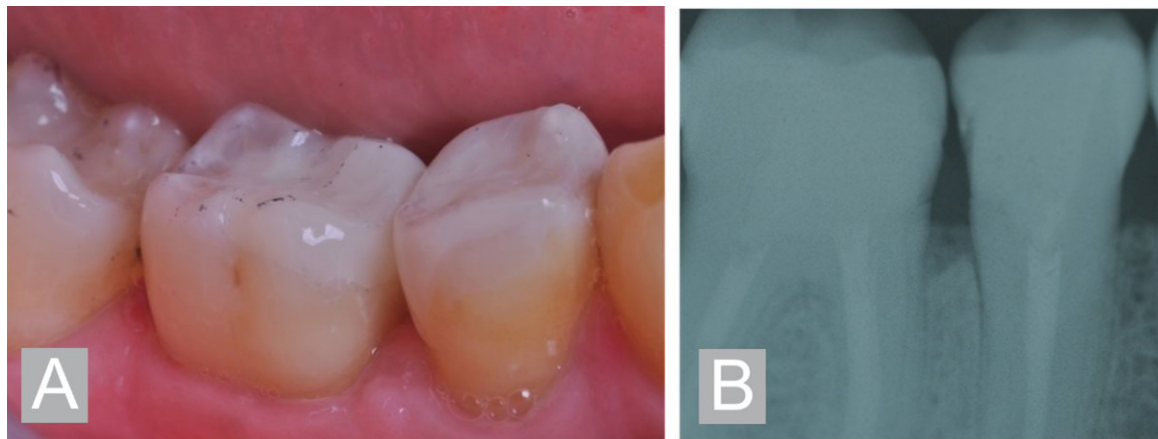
(A) Final aspect of the restorations; (B) Initial and final radiographic aspect of the restorations.
